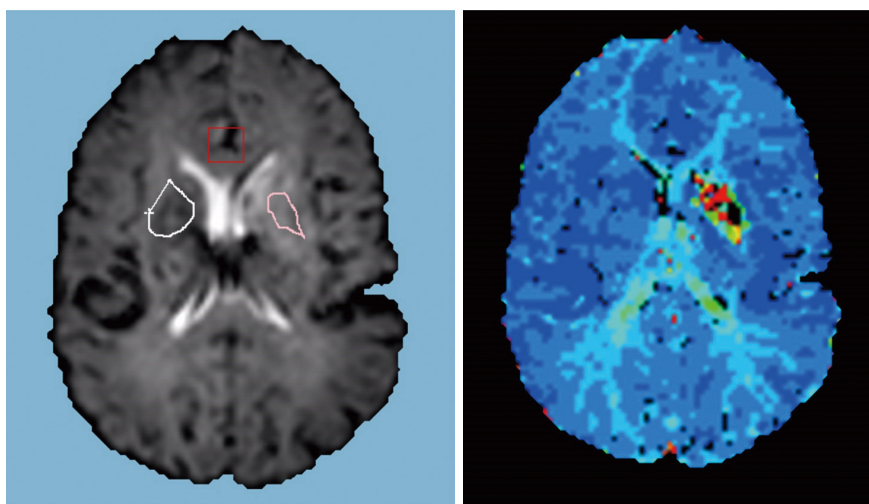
Representative images of perfusion-weighted MRI. The red box marked in the left panel represents the brain stem region; the left marked area indicates the signal characteristics under normal conditions; the marked area on the right represents the high signal characteristics of cerebral infarction. MRI, magnetic resonance imaging.
